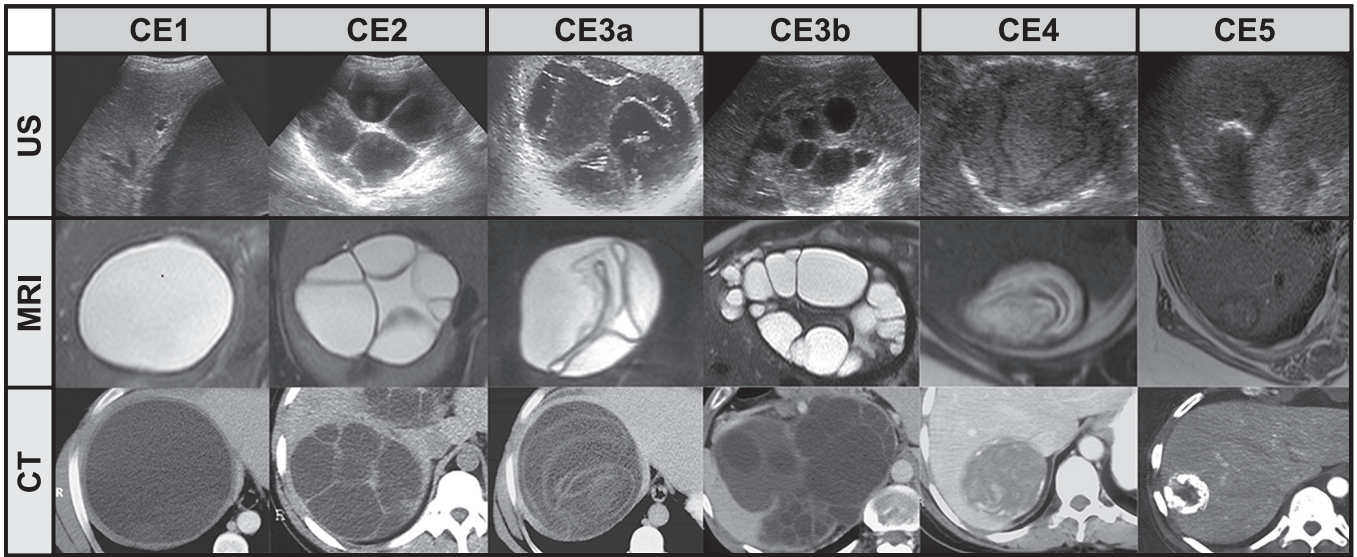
WHO-IWGE (World Health Organization – Informal Working Group on Echinococcosis) classification for liver hydatid cysts. CE1: unilocular, simple cysts with liquid content and often with the CE1-specific “double line sign”, CE2: multivesicular, multiseptated cysts, CE3a: cysts with liquid content and the CE3a-specific detached endocyst, CE3b: unilocular cysts with daughter cysts inside a mucinous or solid cyst matrix, CE4: heterogenous solid cysts with degenerative, CE4-specific canaliculal structure of the cyst content, and CE5: cysts with degenerative content and heavily calcified wall. Note that CE2 and CE3b correspond to GHARBI III classification (fluid collection with septa and/or daughter cysts), and CE3a corresponds to GHARBI II classification. Additional class on WHO-IWGE classification, cystic lesion (CL), corresponds to cyst with no visible wall and homogeneous anechoic content (not shown in the figure). Despite being considered “inactive”, cysts CE4 and CE5 can carry viable scolices. (From: *Stojkovic M, Rosenberger K, Kauczor H-U, Junghanss T, Hosch W* Diagnosing and Staging of Cystic Echinococcosis: How Do CT and MRI Perform in Comparison to Ultrasound? *PLoS Negl. Trop. Dis.* 6, e1880 (2012).⁶²
